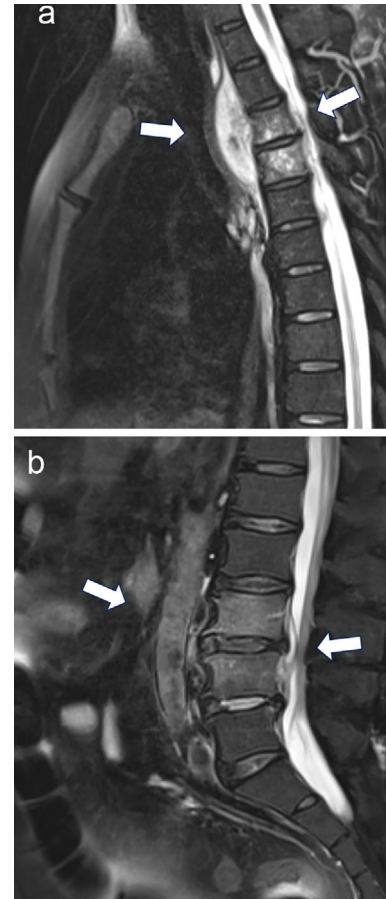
T2-weighted sagittal MRI of the thoracic and lumbar spine showing spondylitis and peripheral abscesses at Th5-6 (a) and L3-4 (b) spinal levels.
